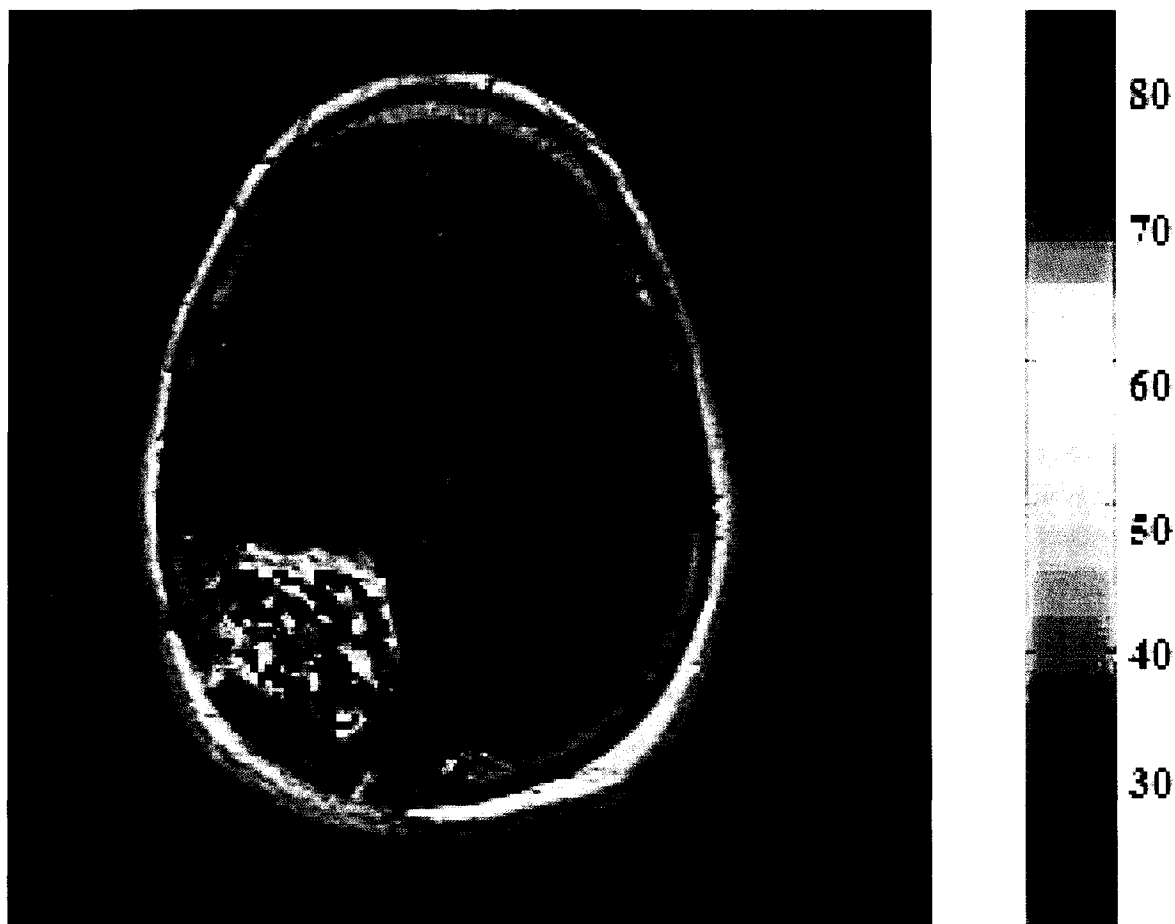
Patient 1: The \mathcal{A} map overlaid on a post-contrast T1-weighted image.
